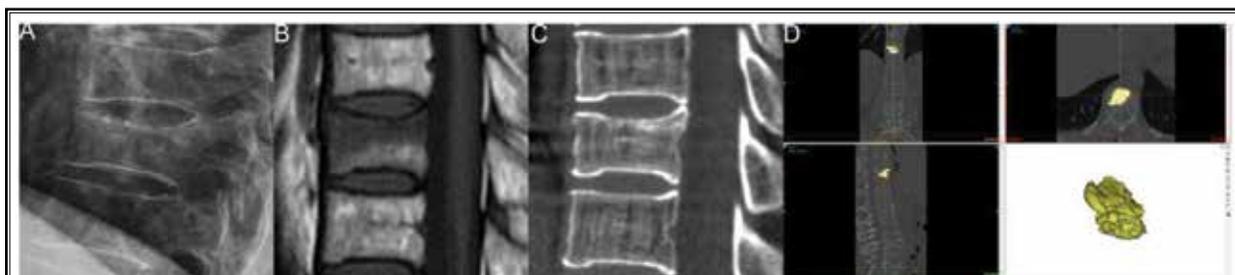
A 63-year-old man with T11 OVCF. A) Sagittal x-ray of the injured vertebra; B) sagittal MRI of the injured vertebra; C) sagittal CT of the injured vertebra; D) model of the bone cement.
